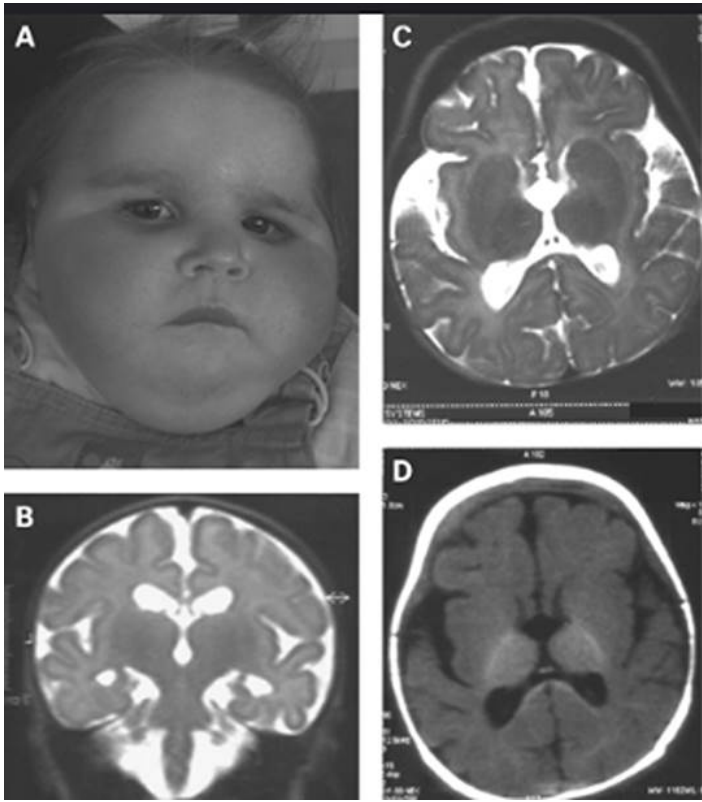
Facial features and MRI features of COFS Syndrome (Photo Credits:) [8]
